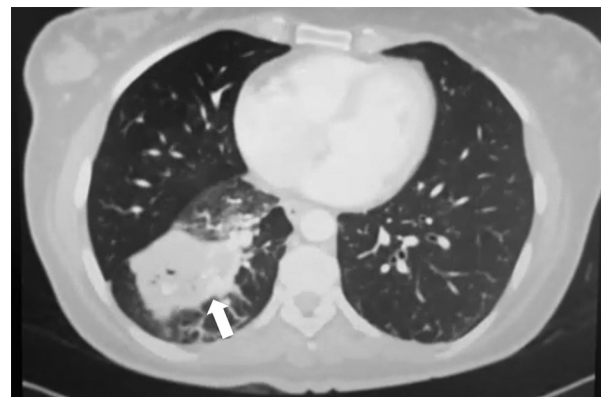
Thoracic computed tomography scan showing large heterogeneous consolidation in the right lower lobe with central areas of air attenuation, macrocalcifications and hematic dense component toward the lower region with perilesional ground-glass opacity.
